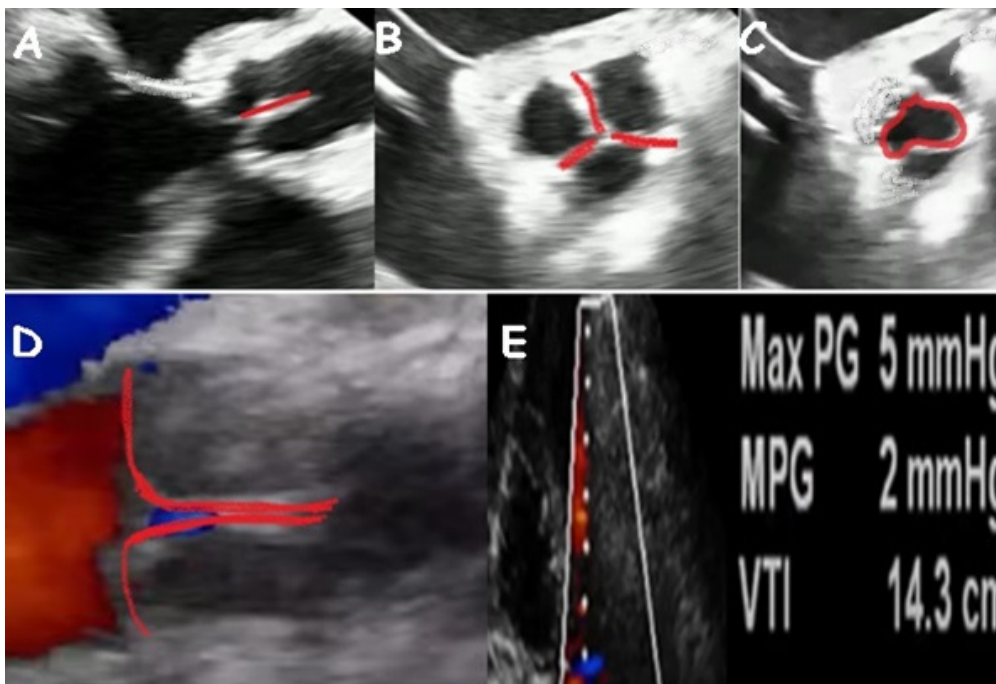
Postoperative echocardiographic assessment showing absence of aortic regurgitation and reduced transvalvular gradient. A: A large coaptation surface when the aortic valve leaflets are closed. B: Appearance of the aortic neocuspid valve when it is closed. C: Large effective aortic orifice area D: Aortic regurgitation, underdeveloped, large coaptation surface. E: Postoperative low aortic gradient.
